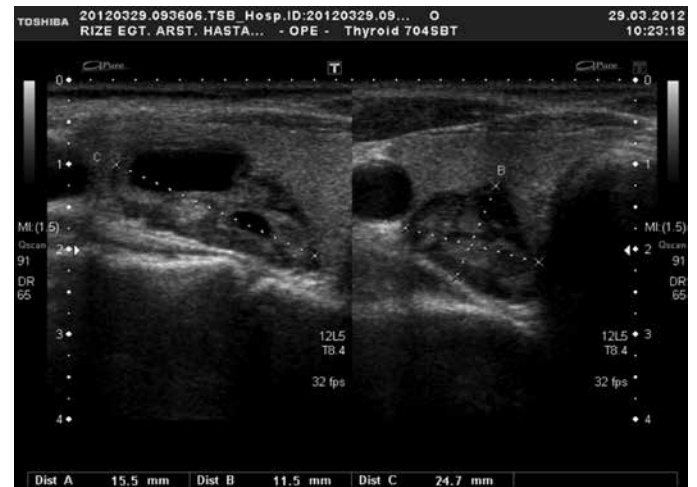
a) Sagittal and b) transverse ultrasound images of thyroid gland show solid parathyroid adenoma in the right lobe of thyroid, with an eccentric cystic area (line arrow pointing to solid portion of the parathyroid adenoma and dashed arrow pointing to an eccentric cystic area)
